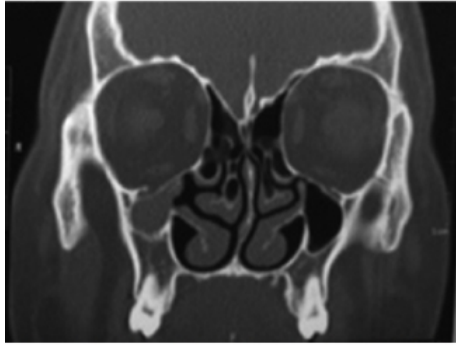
Coronal CT demonstrating maxillary sinus hypoplasia on the right side and maxillary sinus atelectasis on the left side.
